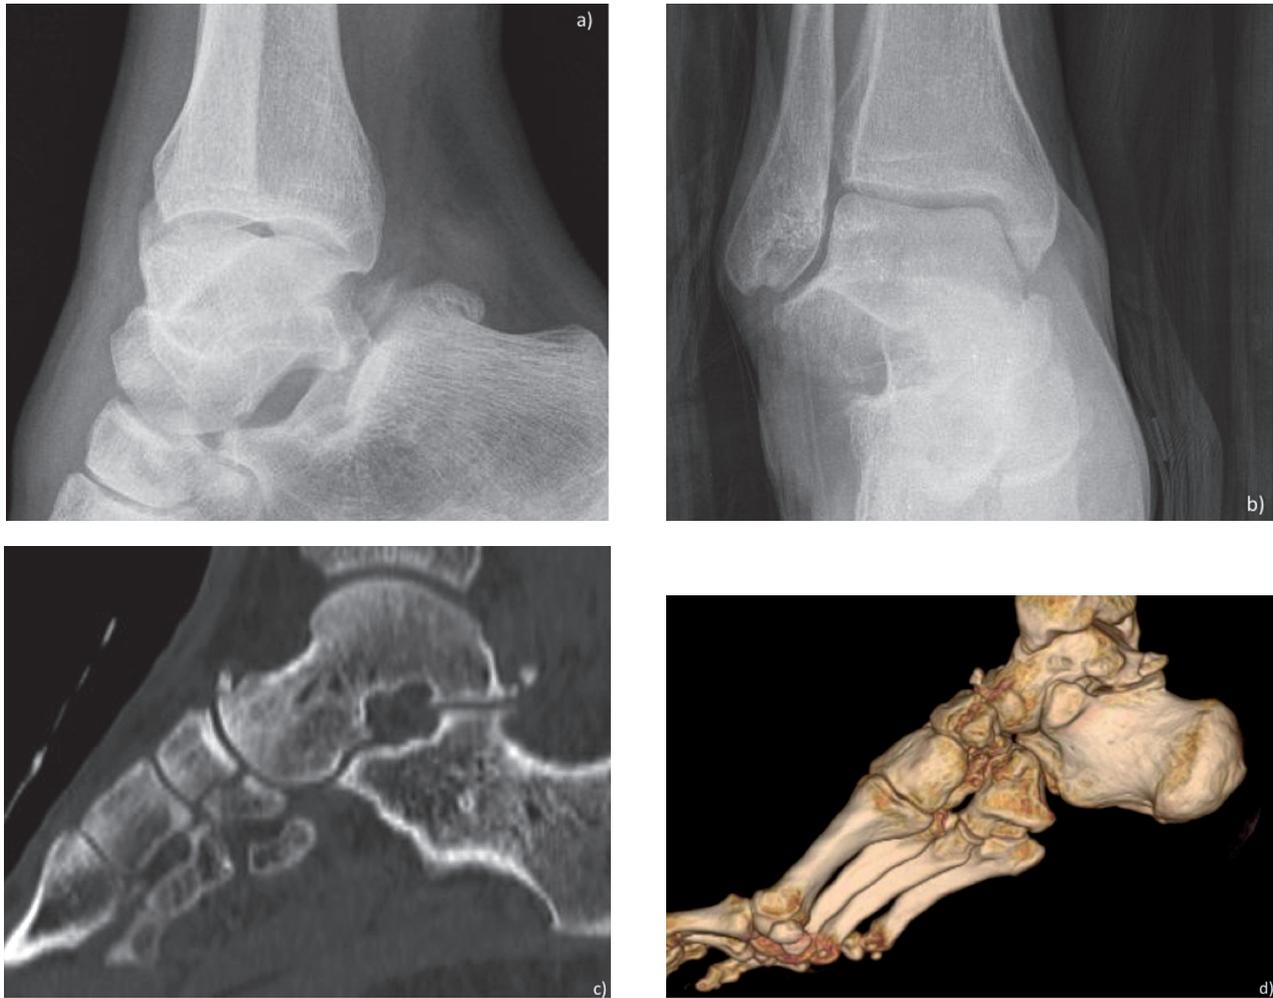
Total talar dislocation. Pre-reduction radiographs (A, B) and post-reduction sagittal CT MPR (C) and VRT reconstruction (D). Post-reduction CT with multiplanar and volume rendering technique reconstructions permits a better detection of displaced fragments, delineation of anatomic relationship and has a higher sensitivity for associated fractures (see the navicular simple fracture in C, not clearly detectable in A)
